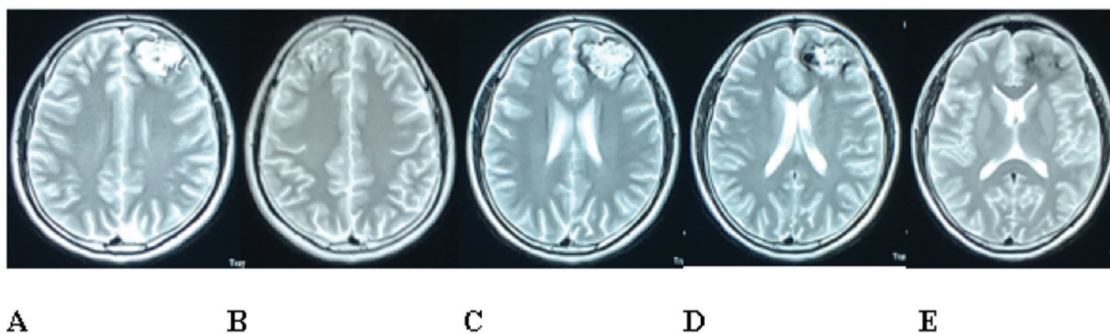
(A-E) MRI (GRE/T2*) showing the presence of multiple areas of hypointense with hyperintense lesions in GRE/T2* sequence indicative of hemosiderin deposition.
